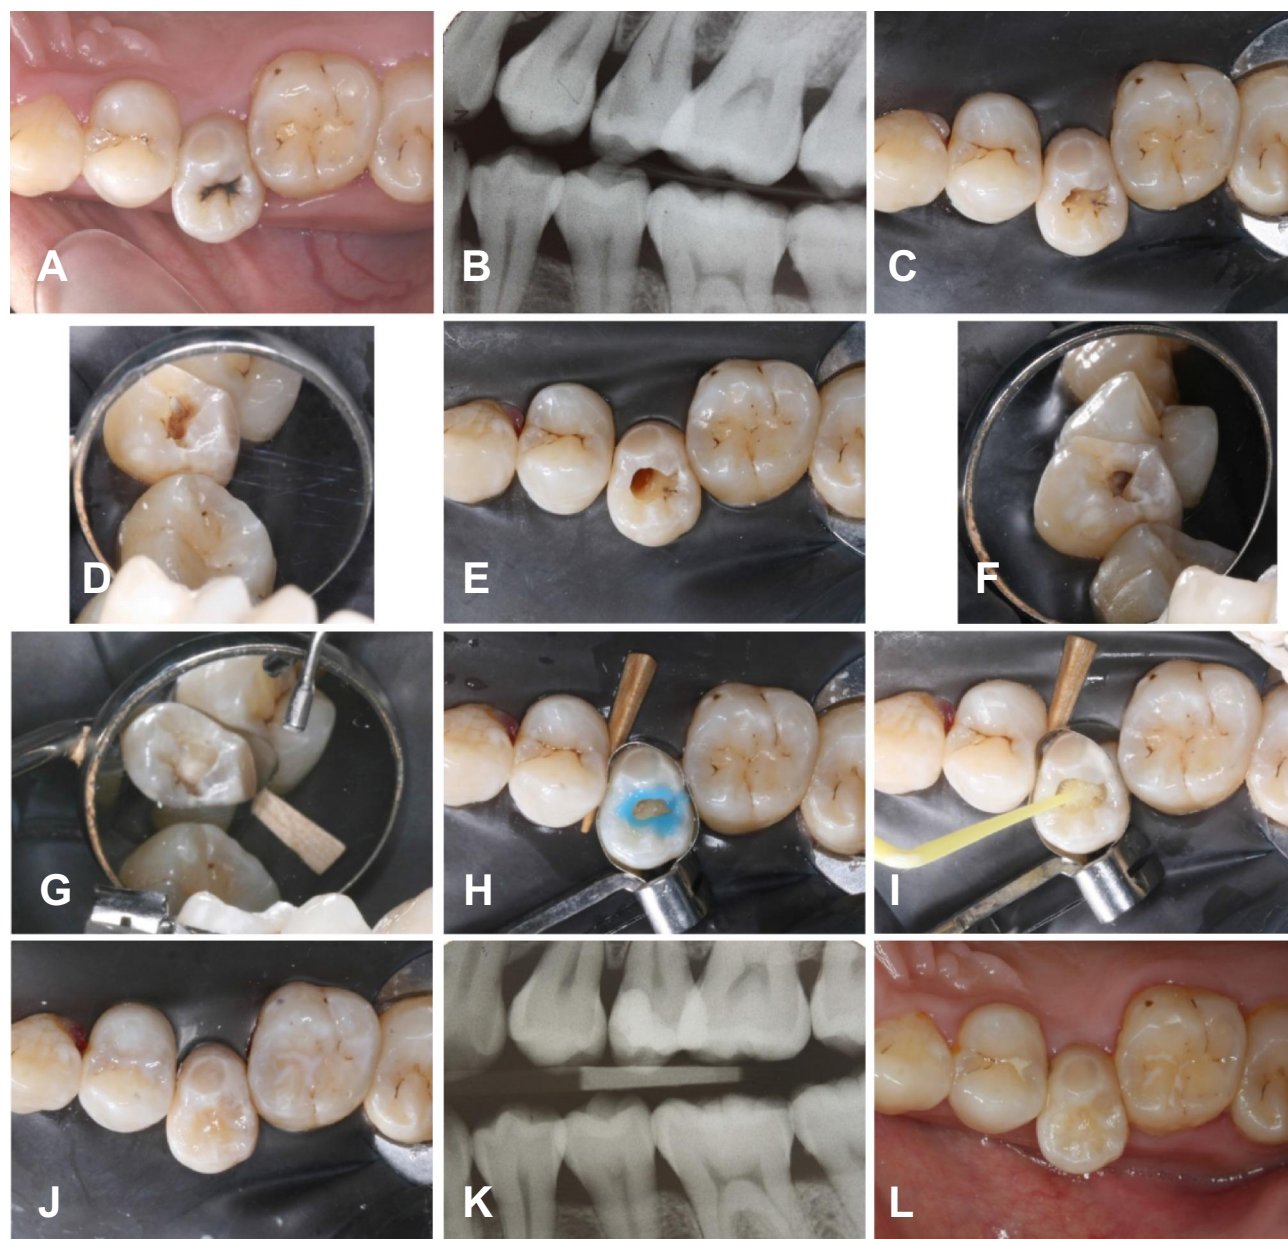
Steps of tunnel restoration in Tooth 15. (A) Occlusal view of 15 before operation; (B) Right bitewing radiography; (C) Occlusal view of the access to the mesial proximal caries; (D) Lateral view of the access to the mesial proximal caries; (E) Occlusal view of the cavity after caries removal; (F) Lateral view of the cavity after caries removal; (G) Restoration of the proximal wall of the cavity; (H) Selective acid-etching on enamel; (I) Bonding agents were applied to the cavity; (J) Restoration of the occlusal cavity; (K) Postoperative bitewing radiograph; (L) Occlusal view after three months.
